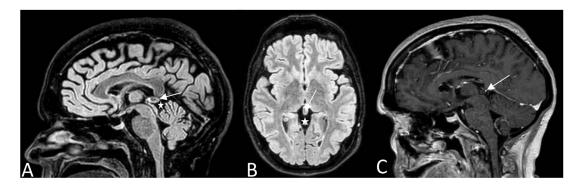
MRI study showing the pineal cyst. (A, B) Hyperintense lesion in FLAIR sequences. (C) T1 Contrast-enhancement sagittal sequence of the lesion. (A) The white arrow points to the cyst wall appearing slightly hyperintense. (B-C) White arrow indicates a cystic lesion in the pineal region. The white star highlights the quadrigeminal cistern (Bichat's canal) that surrounds the pineal gland anteriorly, the splenium of the corpus callosum superiorly, the quadrigeminal tubercles antero-inferiorly and the superior surface of the cerebellar vermis inferiorly (A-B).
